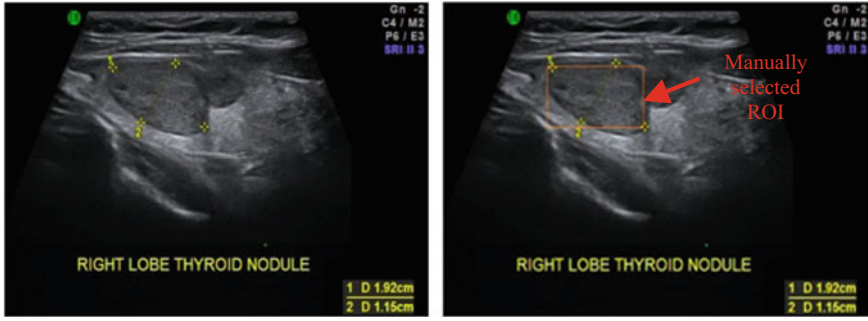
Ultrasound image of thyroid gland (with nodules)
